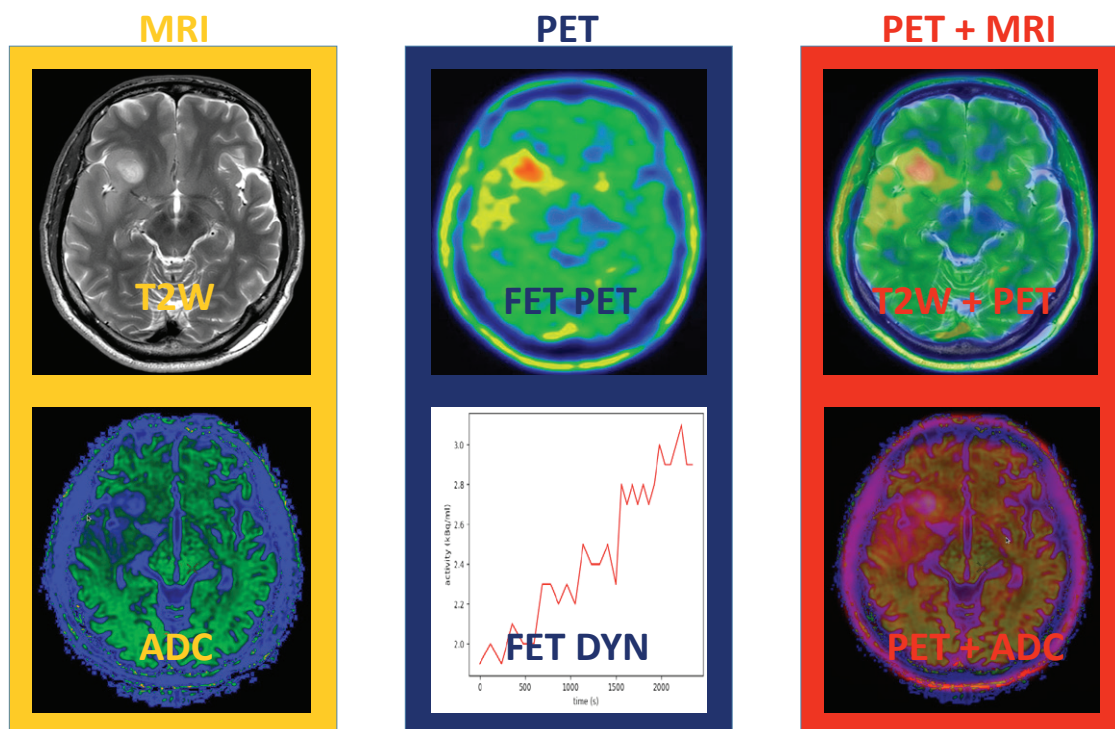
T2W MRI and Fluoro-ethyl-tyrosine (FET) PET in a true simultaneous acquisition allows for exact registration between MR and PET in a single session.
